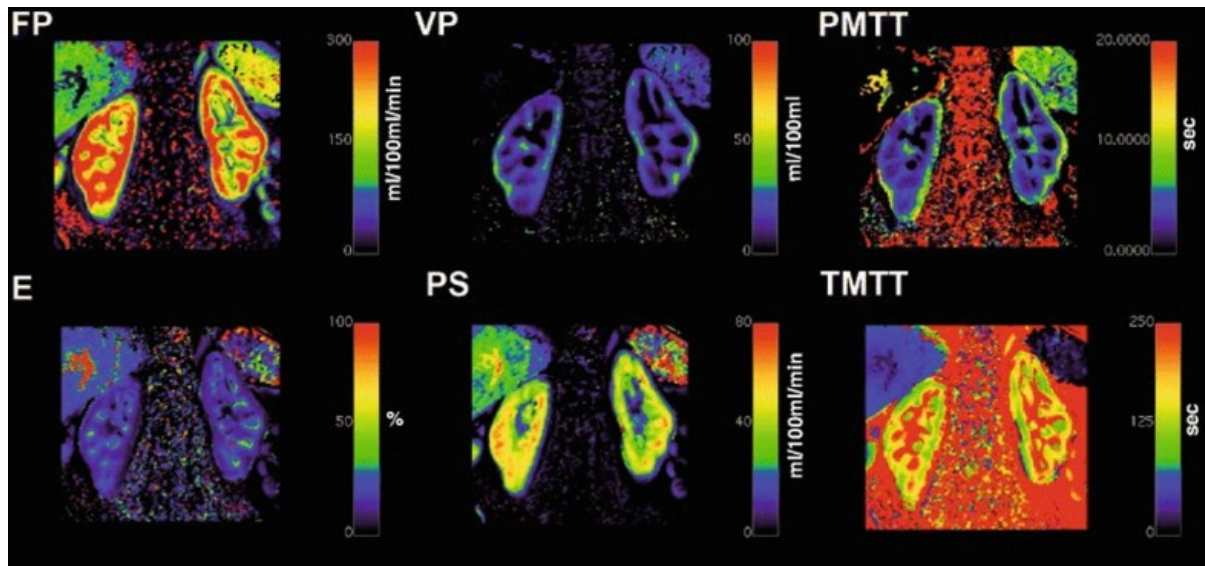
Example of parameters estimated from DCE-MRI in kidneys.
